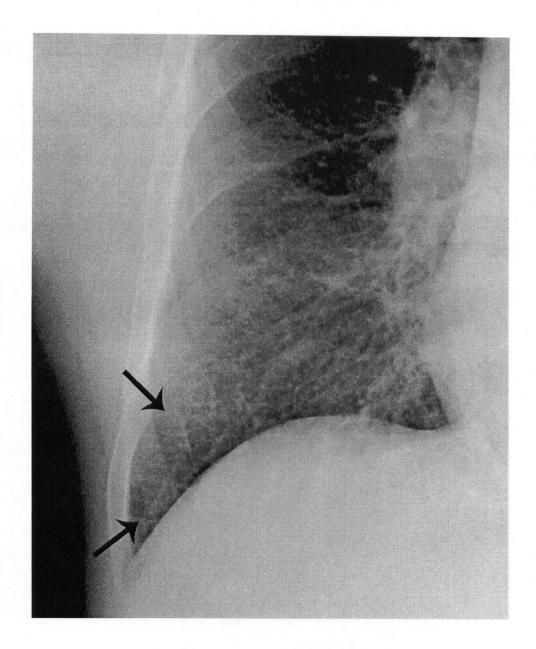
Radiograph of pulmonary oedema. Thickened lymphatic channels in the interlobular septa (arrows) can only be seen in tangent in the periphery of the lung on this chest radiograph of a 61 year old male with mild cardiac failure. The 2 dimensional viewing perspective and the limited soft tissue contrast of the chest radiograph make it impossible to appreciate thickened interlobular septa in other regions of the right lung base.
